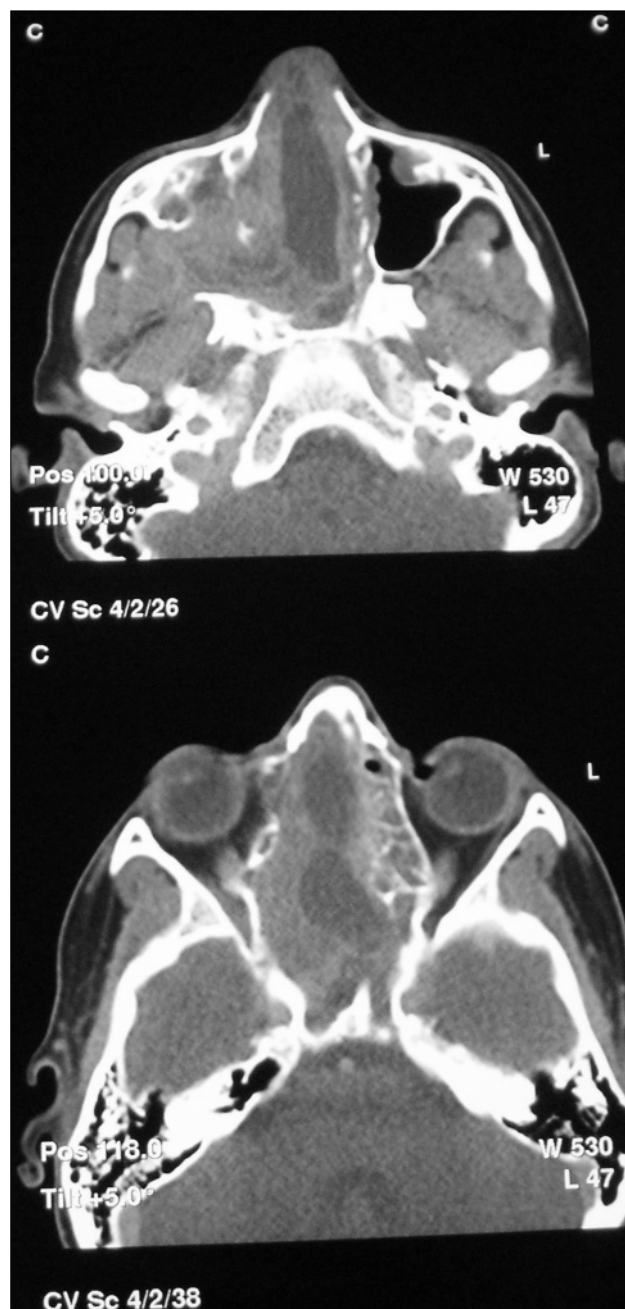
Sagittal plane CT slices revealing the extension of a right maxillary sinus tumor to the ethmoid cells, sphenoid, nasal fossae and skull base
